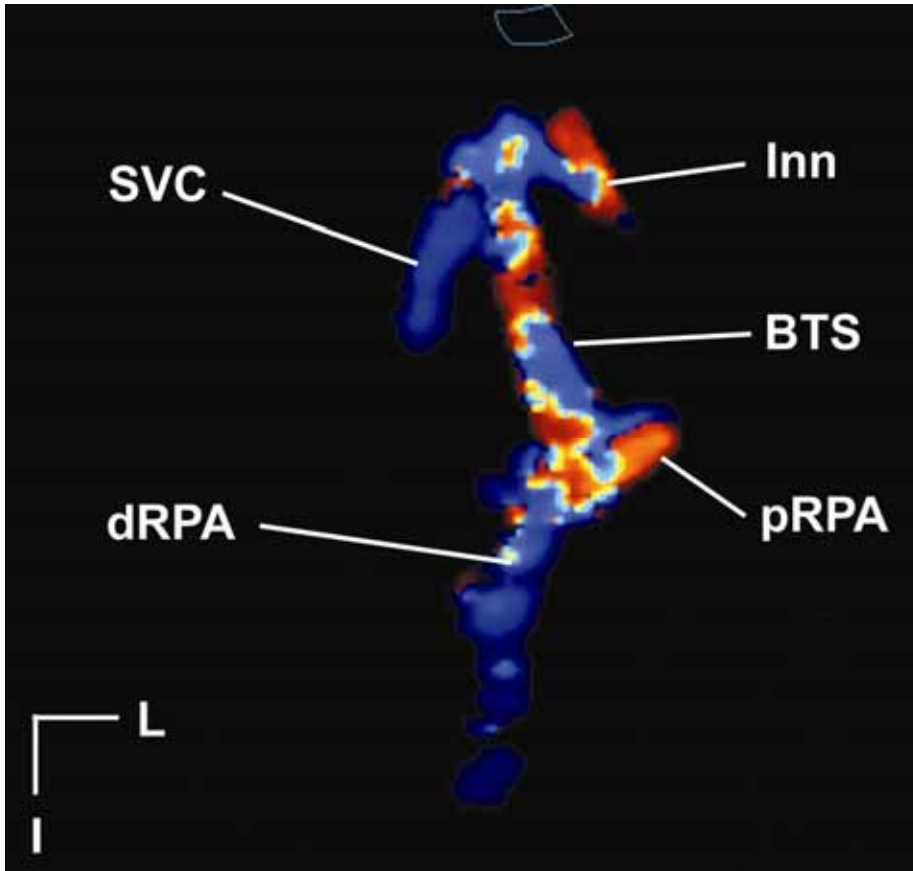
Suprasternal notch view: Echocardiographic 'angiogram' of a modified right Blalock-Taussig shunt (BTS). The grayscale component of the image has been suppressed. dRPA, distal right pulmonary artery; I, Inferior; Inn, innominate artery; L, left; pRPA, proximal right pulmonary artery; SVC, superior vena cava.
